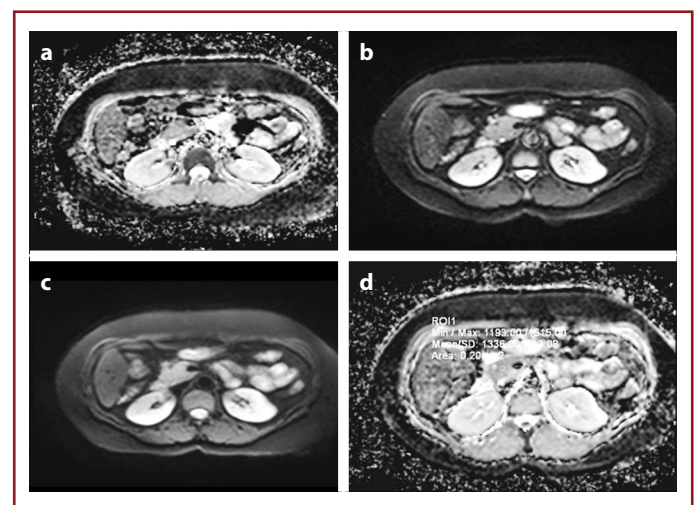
A 37-year-old female patient. A non-breath hold axial DWI obtained with three different b values at the level of the pancreas head: (a) b=0, (b) b=50, (c) b=400 s/mm², and (d) An ADC map calculated with all b values and placement of ROI on the pancreas head.
